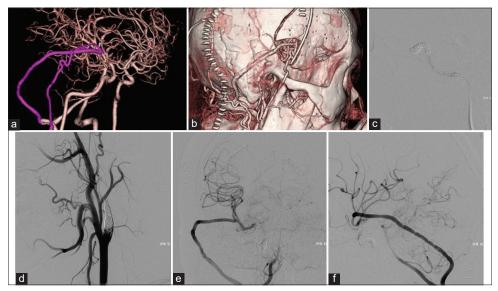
Postoperative courses. (a and b) The reconstruction of the computed tomography angiography in lateral view reveals good filling of the V3-radial artery graft (RAG)-M2 and superficial temporal artery -middle cerebral artery bypass. The internal carotid artery is not occluded at this time. (c) The cavernous portion of the internal carotid artery (ICA) is occluded by coil, lateral view of angiography image. (d) The cervical ICA is occluded, oblique view of angiography image. (e and f) Anterior to the posterior and lateral view of the digital subtraction angiography after ICA occlusion shows good filling of the V3-RAG-M2 bypass.
